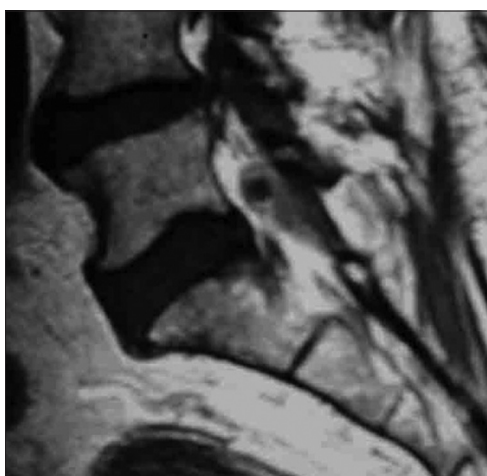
On the T2-weighted parasagittal MR scan of the lumbar spine at the L5–S1 level, the large, isointense, fibrinous capsule of the synovial cyst (isointense mass) contributes to the majority of dorsolateral thecal sac compression, with only a small component coming from the hypointense, fluid-filled cyst
